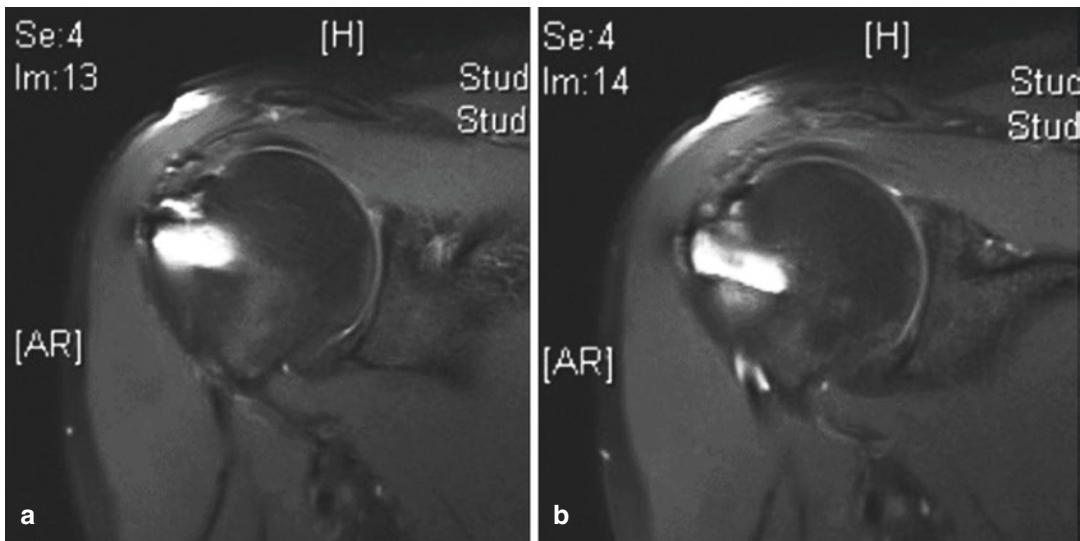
(a, b) MR images (coronal views) 6 months after revision surgery
